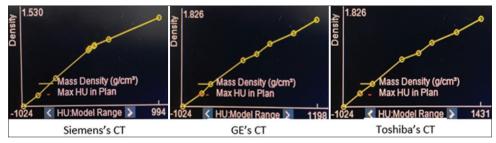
Variation of the Hounsfield units relative electron density calibration curve for Siemens, GE and Toshiba computed tomographies
